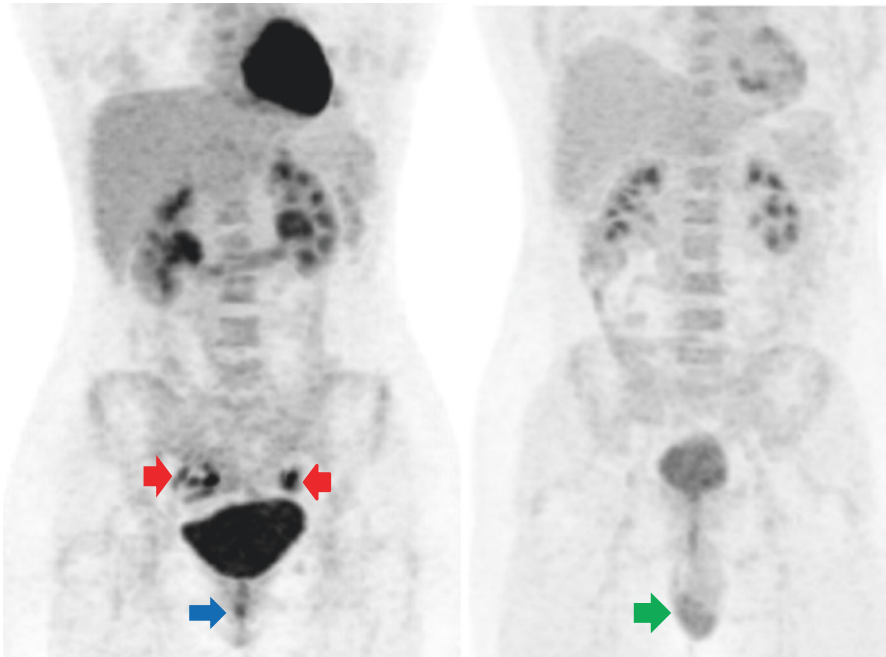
Physiological FDG uptake in the abdomen and pelvis: Usually most intense FDG activity is noted in the pelvicalyceal system, ureters, and urinary bladder. Physiological but less intense FDG uptake is noted in the liver, spleen, bone marrow, and renal cortices. Physiological (variable) FDG uptake may be seen in the uterus and ovaries (*red arrows*) depending on the phase of menstrual cycle. Physiological (low to moderate grade) FDG uptake may be seen in the testes (*green arrow*). Focal FDG uptake at the anus (*blue arrow*) is due to sphincter activation or local inflammation
